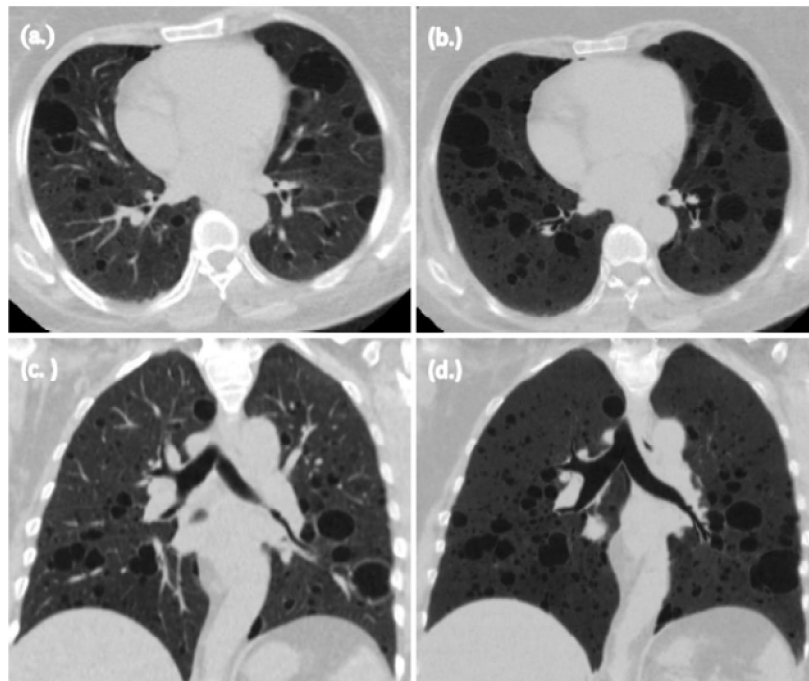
A 48 years old female (known Lymphangioliomyomatosis) presented with dyspnea, there is history of left nephrectomy due to benign mass lesion (Angiomyolipomas) with ectopic malrotated right kidney and hepatic focal lesions of benign nature Axial Section and coronal reconstruction of non-contrast CT chest scan (a, c) Volumetric HRCT shows multiple variable sized thin walled cystic lesions seen distributed throughout both lung fields; note how the cystic lesion are more evident in (b, d) MinIP projection images even small cysts that could not be visualized in HRCT are visible in MinIPs.
